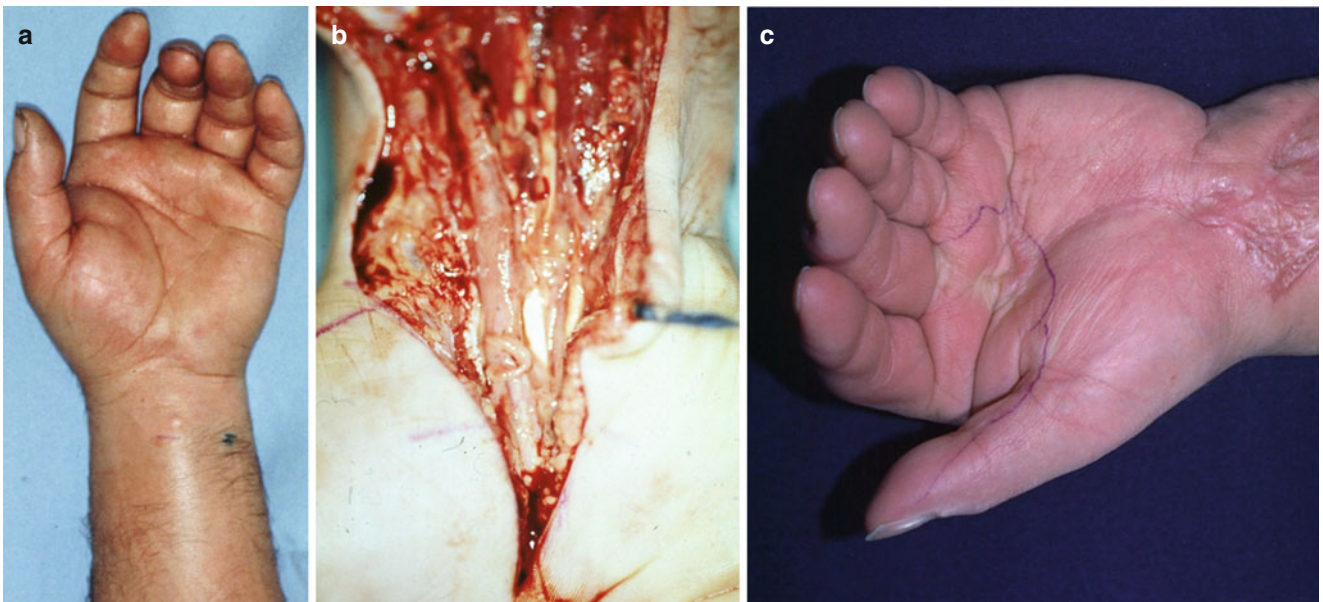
Acute carpal tunnel syndrome: (a) Local painful swelling of the left volar wrist, sensory loss in median nerve distribution. (b) After confirmation with ultrasound, the median nerve was released. (c) Residual deficits were a sensory loss of the volar sides of the fingers (marked with a ball pen)
